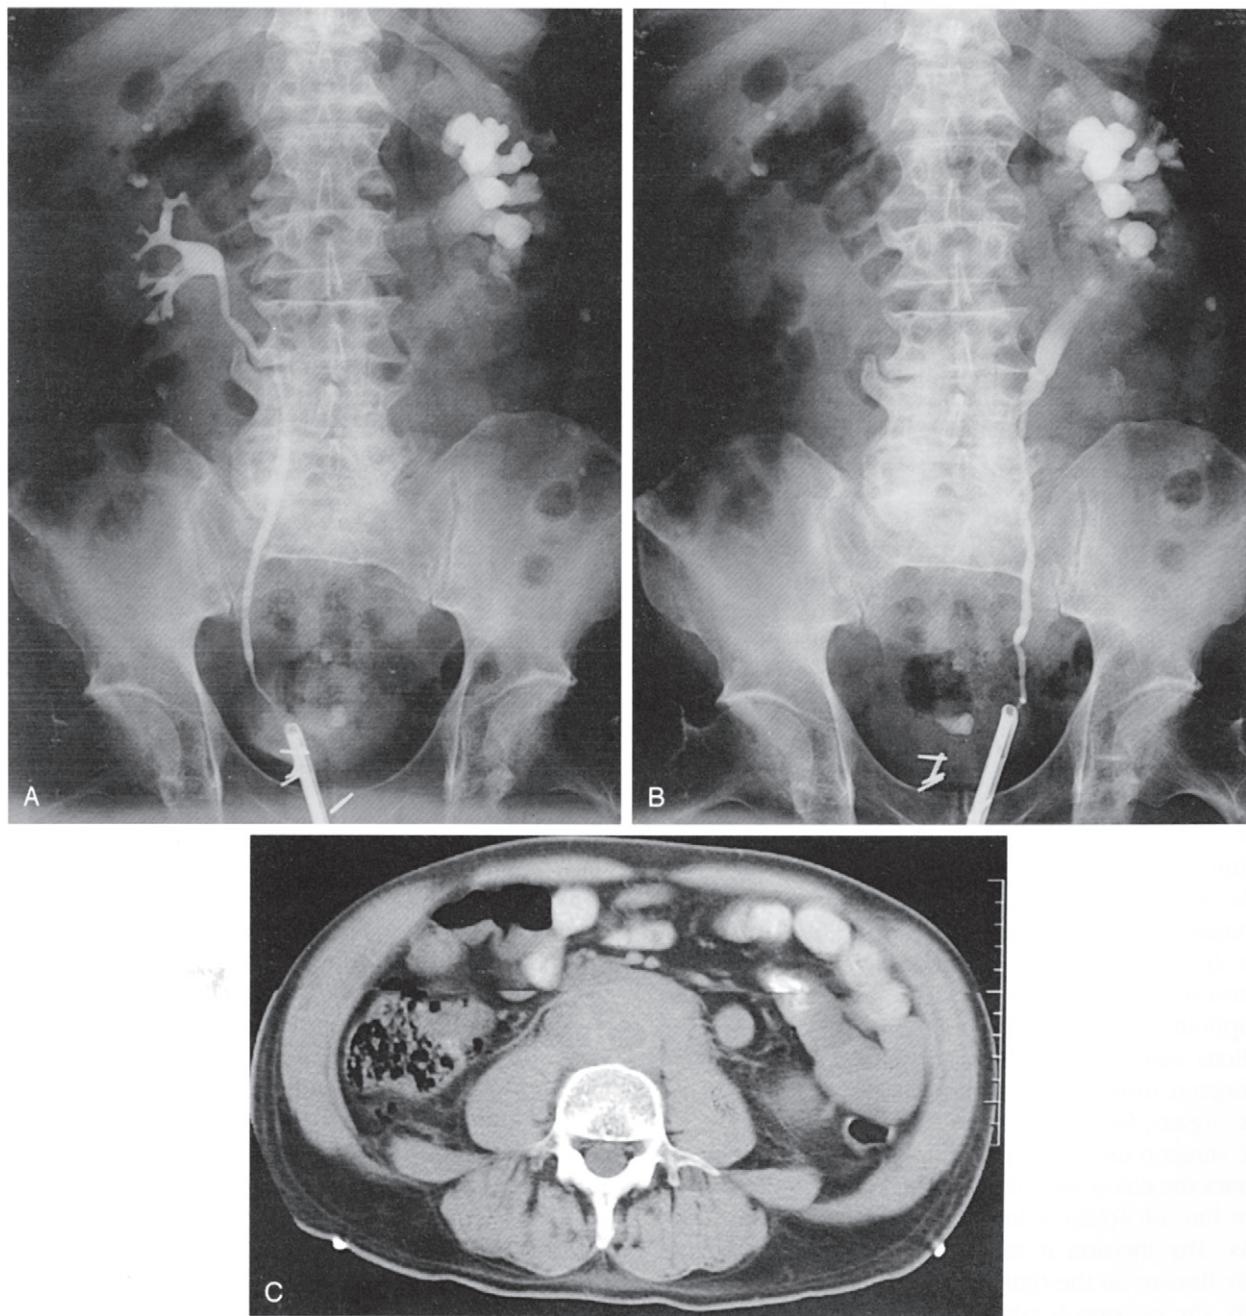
Retroperitoneal fibrosis. *A*, Right-sided retrograde ureterogram shows medial displacement of the mid ureteral segment. *B*, Left-sided retrograde ureterogram shows medial displacement of the ureter in the same area as the right side. *C*, A CT scan demonstrates the area of dense fibrosis causing ureteral obstruction.
